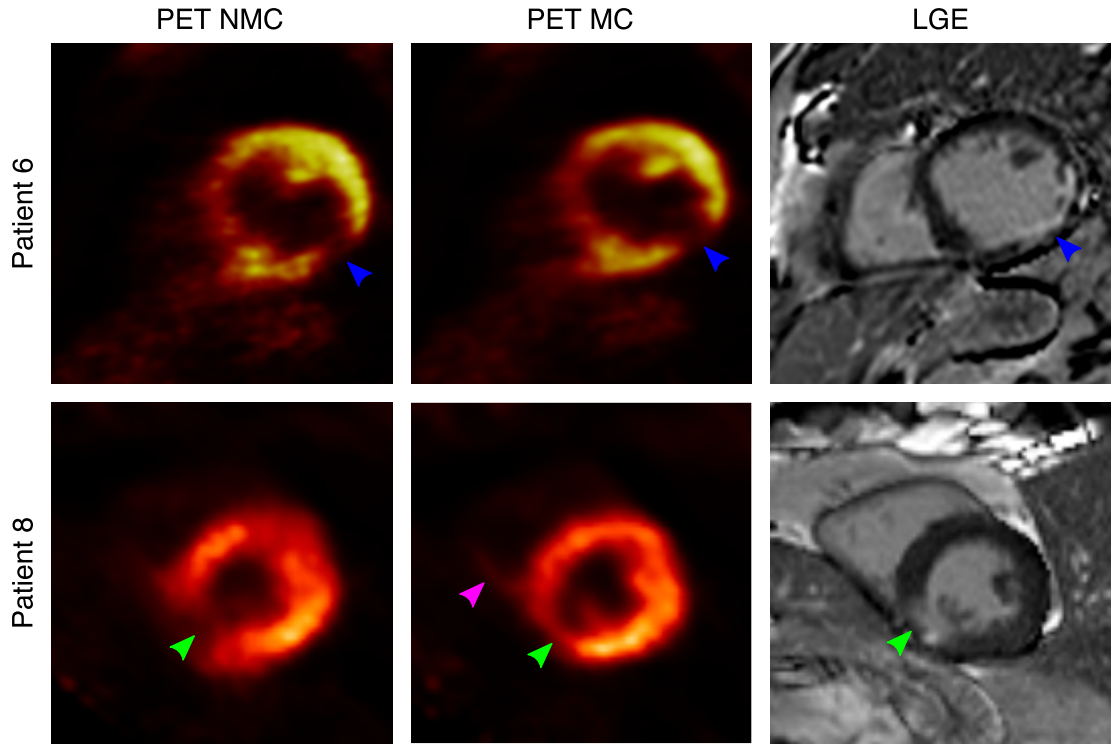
Short axis view for 2 representative patients (rows) showing uncorrected (NMC) and motion-corrected (MC) viability ^{18}F -FDG PET images, and corresponding conventional 2D LGE-MR scans. MC improves the correspondence of the PET images to the anatomy as observed in the LGE images, particularly in the delineation of viability defects (green and blue arrows) and right ventricle myocardium (pink arrow).
